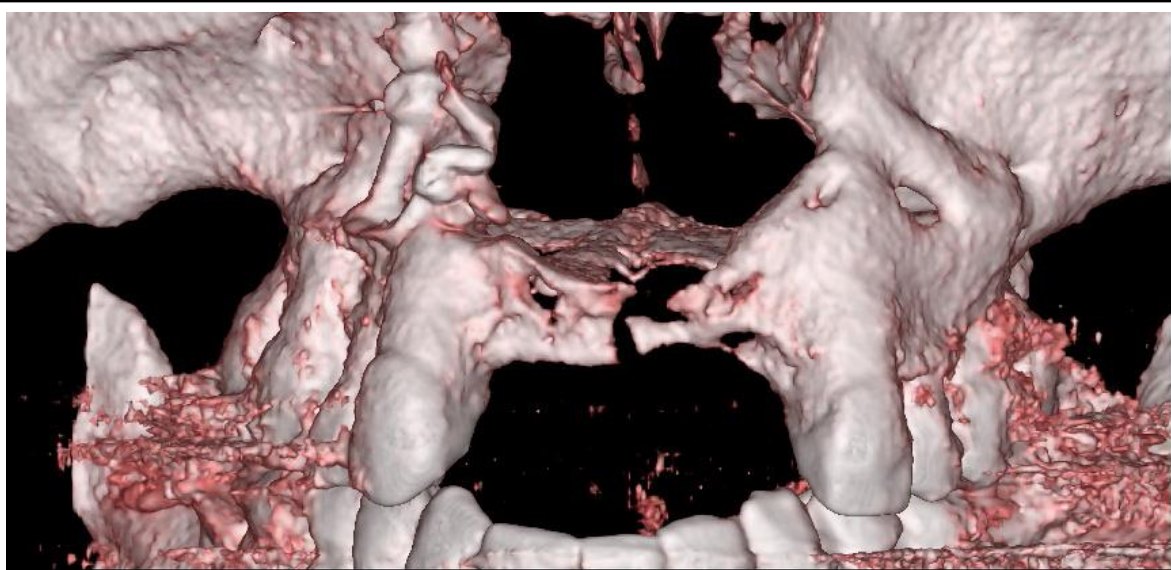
CBCT reconstruction of patient HS showing inadequate bone volume for implants
